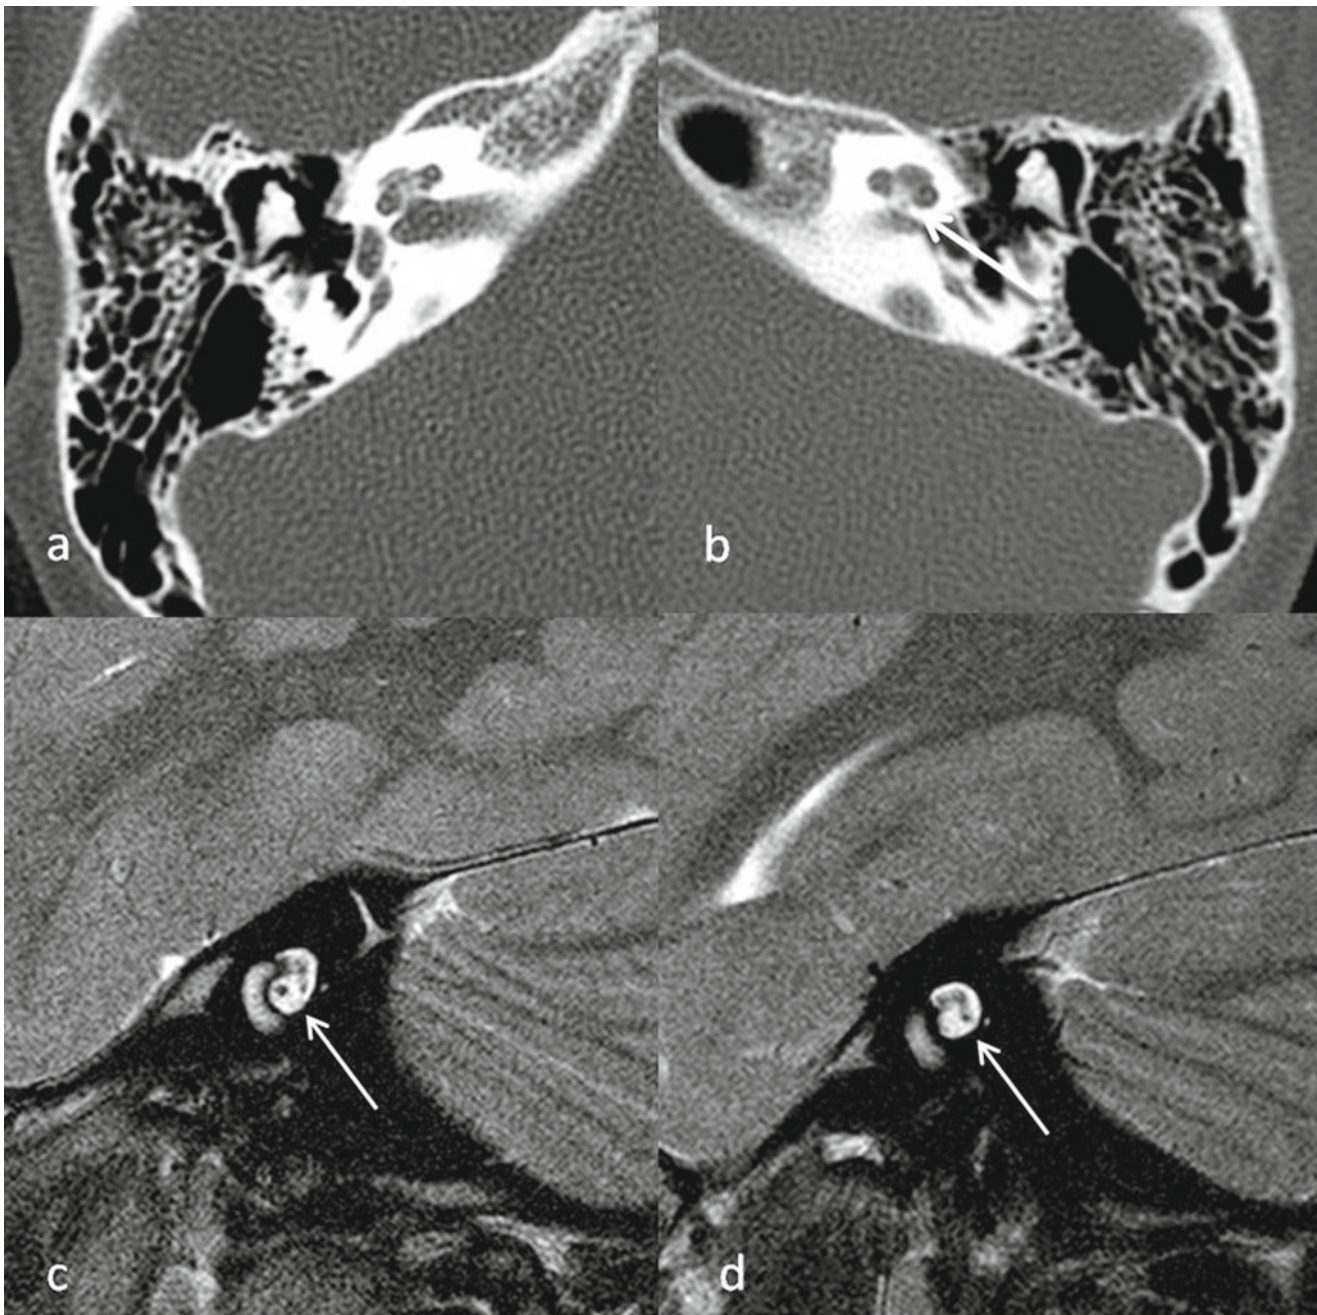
Example of bony plate obstructing cochlear canal, the entry-way into modiolus of cochlea. Axial CT: (a) right ear with normal cochlear nerve canal; (b) left cochlear nerve canal obstructed by a bony
